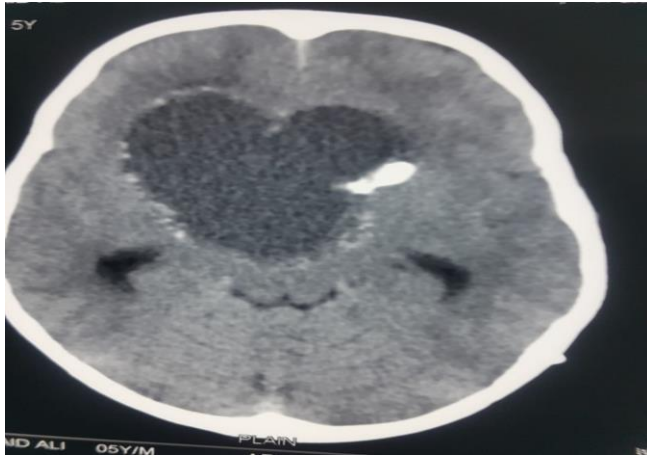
CT Brain showing that Ommaya Reservoir in Cystic Portion.
